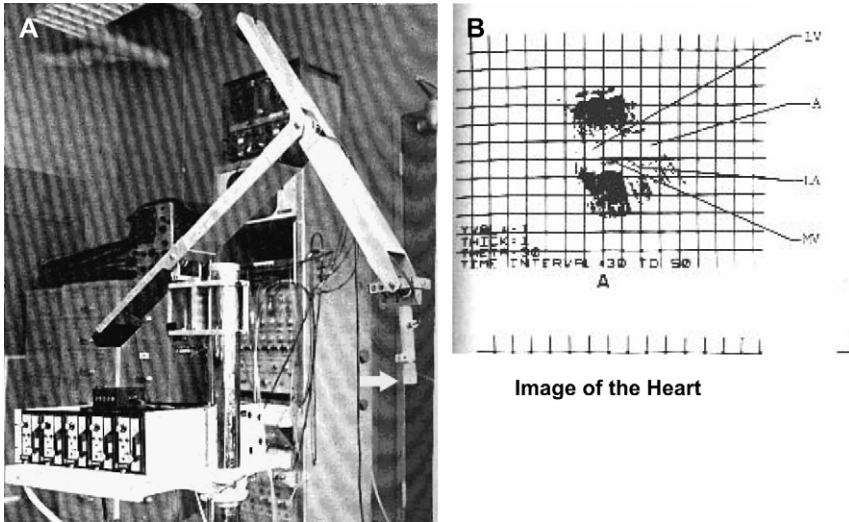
(A) The mechanical arm. A large external beam device gives spatial data regarding an ultrasound probe to enable 3D reconstruction. The ultrasound probe is depicted by the arrow. (B) The image that resulted from the mechanical arm 3D reconstruction. Note that the image is barely discernible as a cardiac structure.
